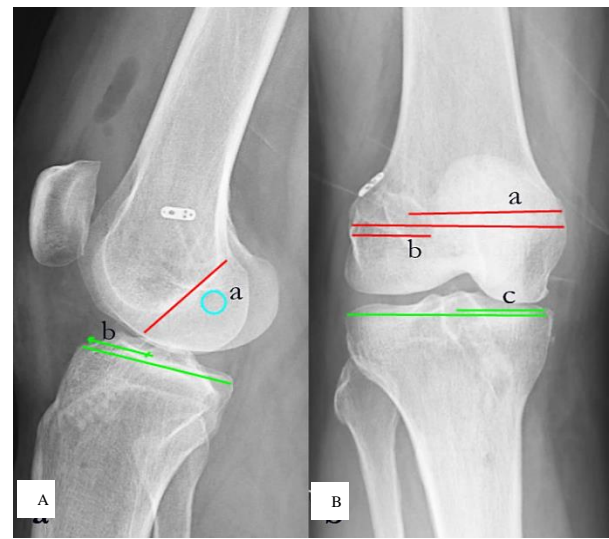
A. Lateral radiograph of the knee- a: femoral tunnel relation to Blumensaat's line (red line), b: distance from the anterior border of the tibial plateau to tibial tunnel center; B. Anteroposterior radiograph of the right knee- a: distance from medial border of the medial condyle to center of femoral tunnel, b: distance from lateral condyle to femoral tunnel center, c: distance from medial border of the medial plateau to tibial tunnel center
